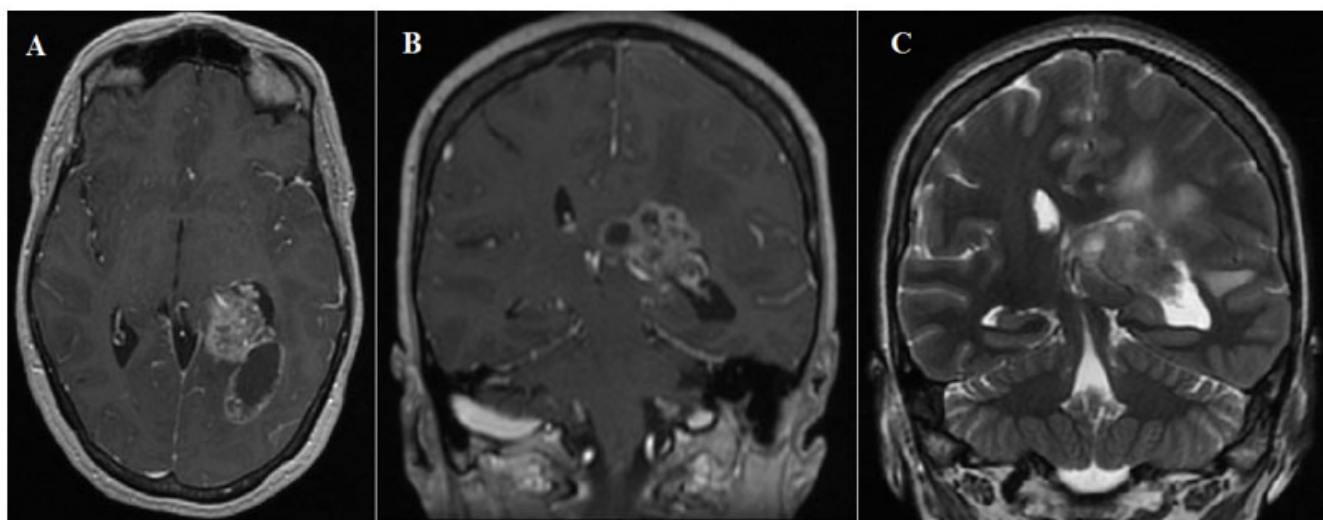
(A & B) MRI axial and coronal post contrast T1 weighted images demonstrating multilobulated mass with heterogeneous enhancement within the left occipital horn. (C) Coronal T2 weighted image demonstrating the surrounding vasogenic edema and mass effect with midline shift.
